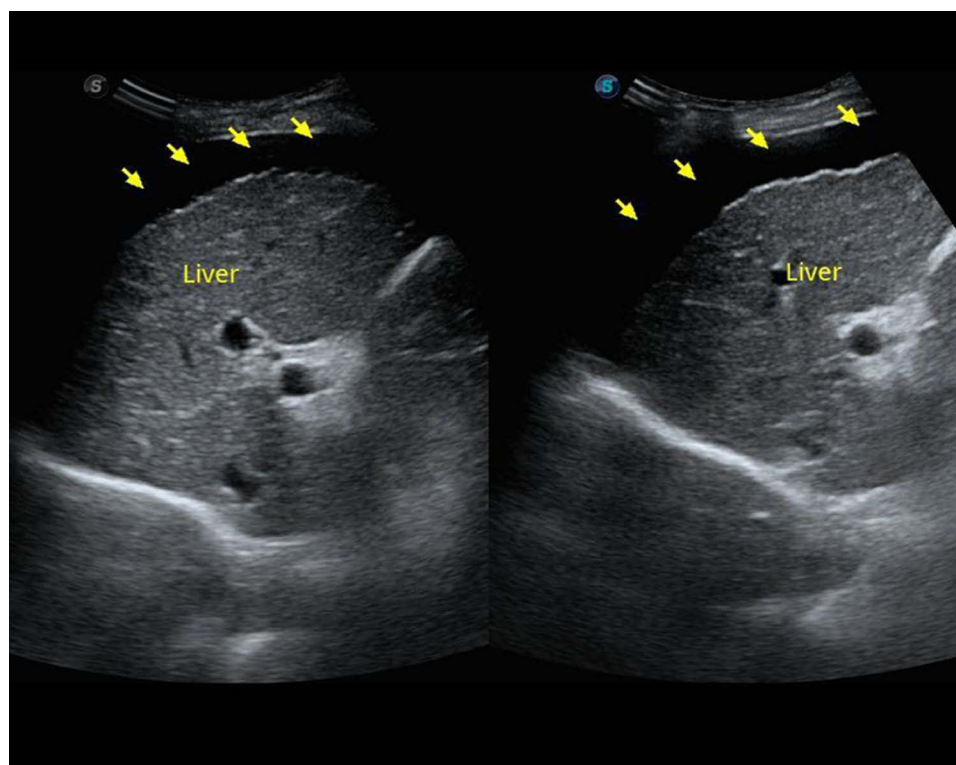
Abdominal Ultrasound showed massive Ascites, the yellow arrow indicates ascites.
